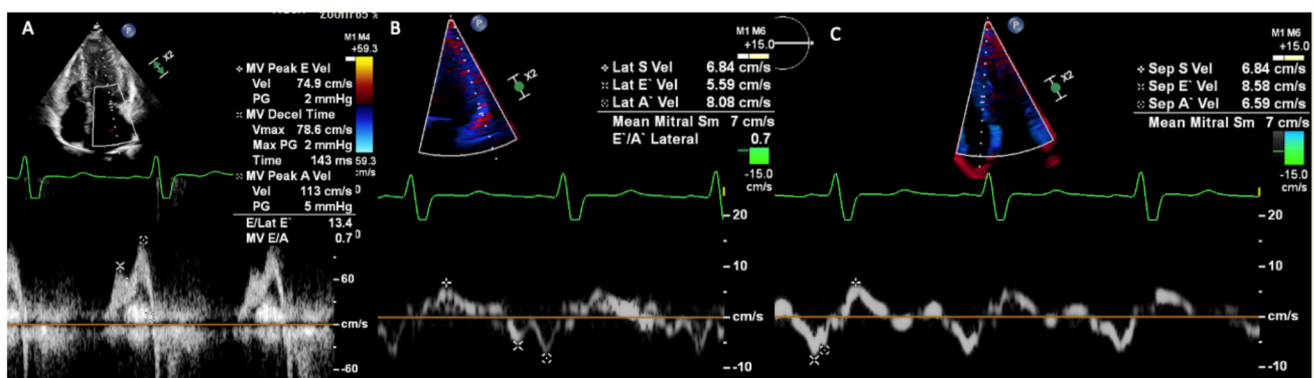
Pulsed-wave Doppler and TDI TTE in a patient with Fabry cardiomyopathy. (A): Pulsed-wave Doppler through the mitral valve leaflets showing E/A 0.7 and deceleration time 143 ms with LA dilatation; (B): Lateral TDI showing reduced lateral s' and e' velocities; (C): Septal TDI showing reduced septal s' and e' velocities.
